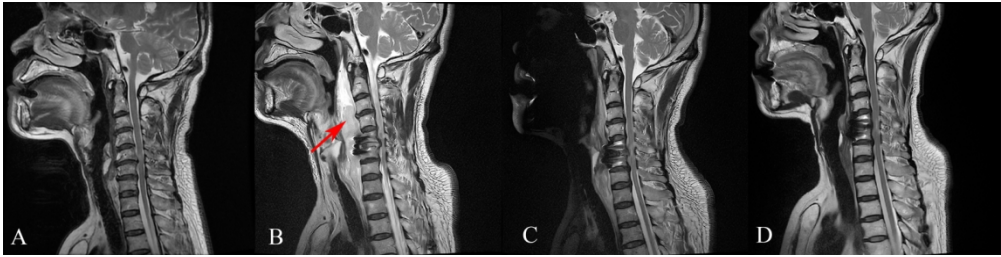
A 67-year-old man developed postoperative RH after C5/6 ACDF. (A) Preoperative sagittal T2-weighted MRI showed a disc herniation at C5/6 with spinal cord compression. (B) Sagittal T2-weighted MRI at 24h postoperatively showed RH extending from C2 to T1 (arrow head). (C) Sagittal T2-weighted MRI at 3 days postoperatively showed RH apparently eliminated after hematoma evacuation. (D) Sagittal T2-weighted MRI at 3 months postoperatively showed the recovery of prevertebral soft tissues to a normal state. RH, retropharyngeal hematoma; ACDF, anterior cervical discectomy and fusion; MRI, magnetic resonance imaging.
